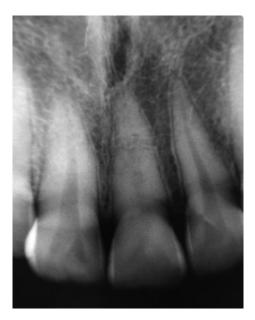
Radiograph obtained 5 years after the first examination.
